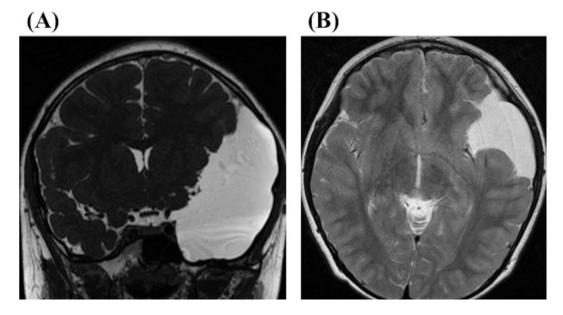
A 9-year-old boy complained of headache presented with a huge arachnoid cyst located in the middle cranial fossa. MRI (A; coronal section on fast imaging employing steady-state acquisition (FIESTA), B; axial section on T2 weighted image (WI)) showed that the arachnoid cyst compressed the surrounding cerebral parenchyma and bulged onto the temporal convexity. Although a light motor retardation had been recognized on preoperative neurological examination, it improved after endoscopic fenestration between the cyst and the carotid cistern.
